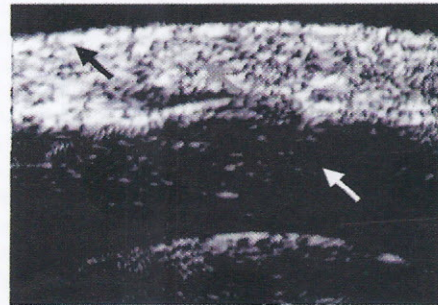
Ultrasound scan of healthy skin. Epidermal entry echo (black arrow), dermis (white arrow) subcutaneous tissue (grey arrow).
